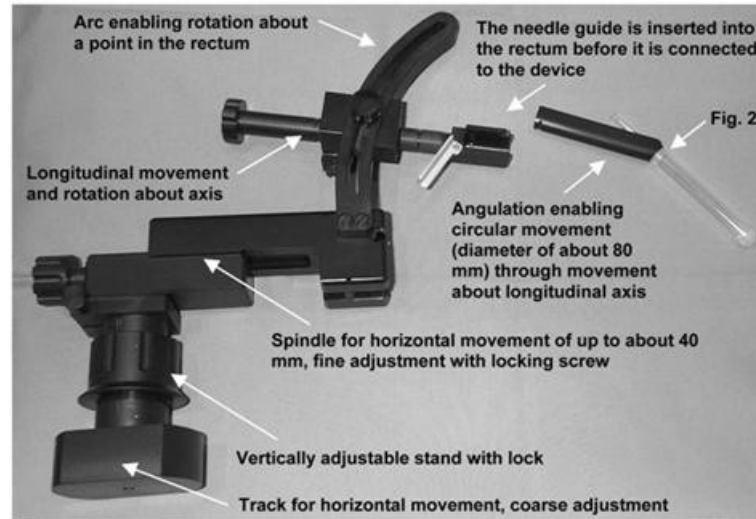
Early prototype of the Invivo MRI-guided prostate biopsy positioning arm. Each degree of freedom (DOF) is directly actuated by the operator when the mechanism is outside the scanner [Beyersdorff, 2004].
